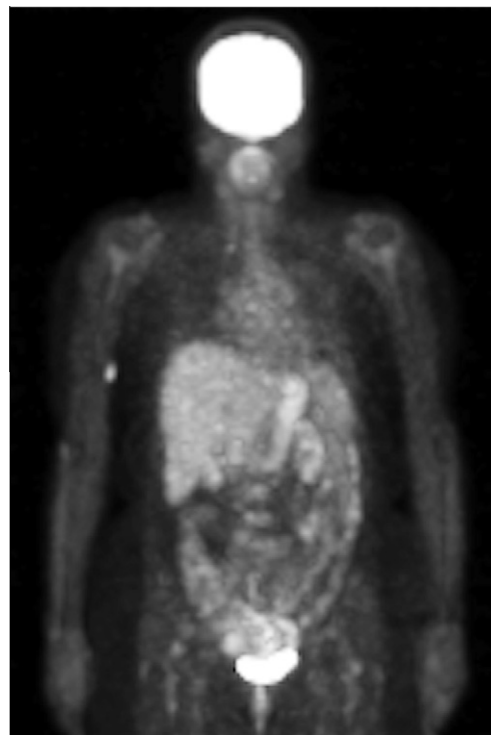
Baseline PET in a patient with lacrimal gland MALT lymphoma shows a focal area of increased FDB uptake in the right arm. An MRI of the upper extremity was subsequently done and confirmed the presence of a lesion in the biceps muscle which upon biopsy proved to be a focus of lymphoma.
